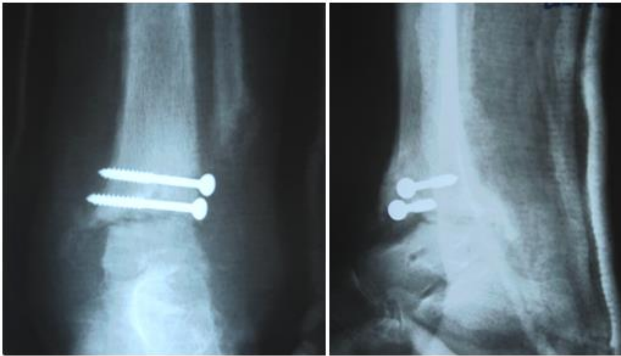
X-ray aspect 3 months after surgical intervention
